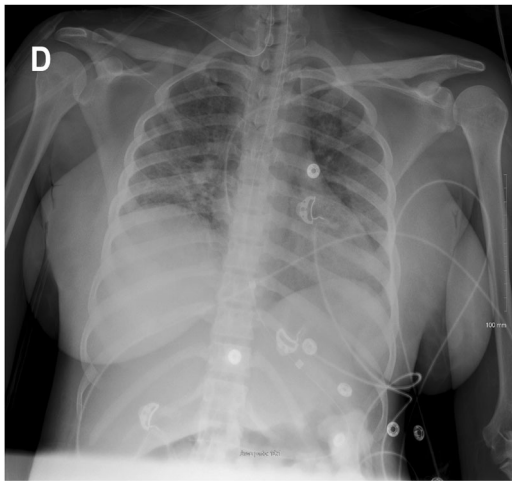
An initial chest X-ray showing massive lung damage corresponding to COVID-19 infection. (A) Jugular cannula. (B) Venous cannula. (C) Protective lead for the fetus
